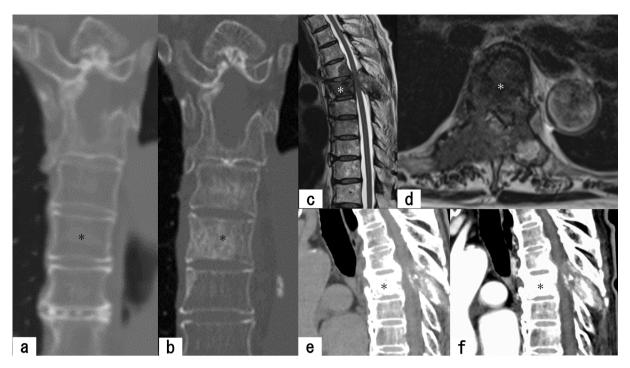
(a) Coronal image of incidental thoracic CT showing no obvious lesions. (b) Twenty-six months later coronal thoracic CT shows ossifying changes in the vertebral bodies of the 5th and 6th thoracic spine. ; the 6th thoracic spine. (c) Sagittal and (d) axial images of spine MRI show tumor compressing the spinal cord around the 6th thoracic vertebra. (e) Sagittal image of plain CT shows mixed osteolytic changes in the lamina and ossifying changes in the vertebral bodies. (f) Sagittal image of enhanced CT does not show a strong enhancement effect.
